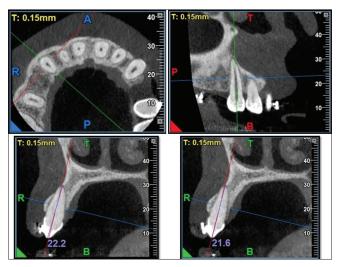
Axial-guided navigation and measurement of root lengths on sagittal section of CBCT
